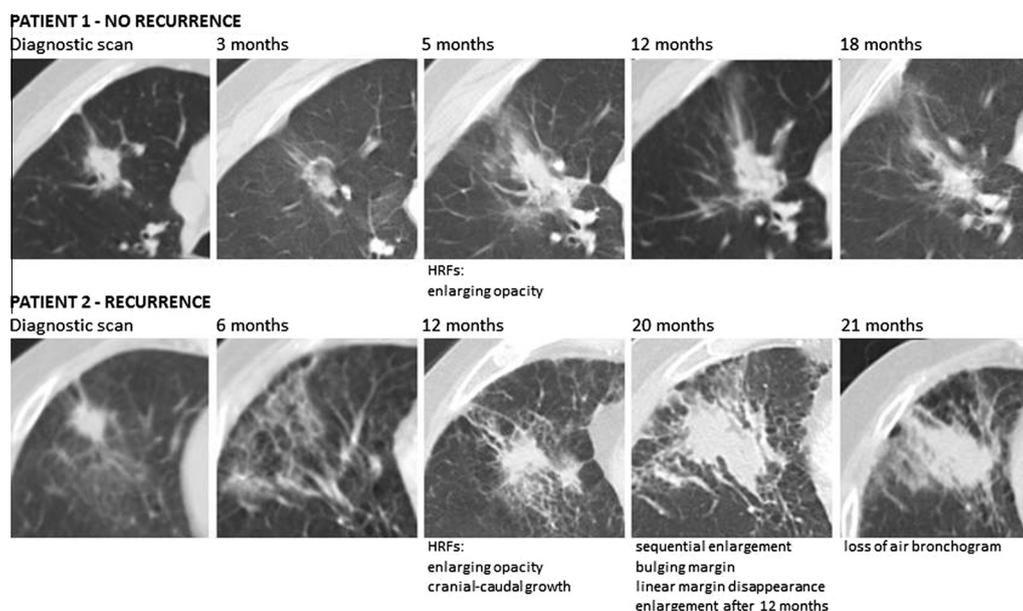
Use of high-risk features (HRFs) on CT to diagnose recurrence. In patient 1, a 5 month follow-up CT shows an enlarging opacity, with additional scans showing fibrosis with no additional HRFs. No evidence of local recurrence. In patient 2, diffuse consolidation is demonstrated at 6 months. Additional HRFs are demonstrated after 12 months. The patient was diagnosed with a local recurrence at 21 months and underwent salvage lobectomy shortly after.
